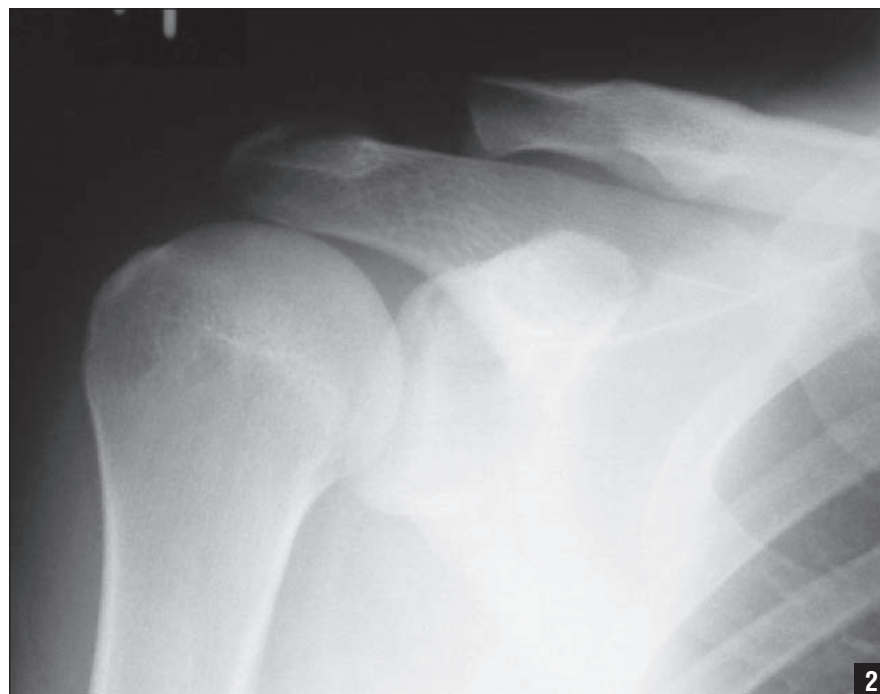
Three-month postoperative radiograph, demonstrating distal clavicle excision without evidence of further bony lysis or erosion.
